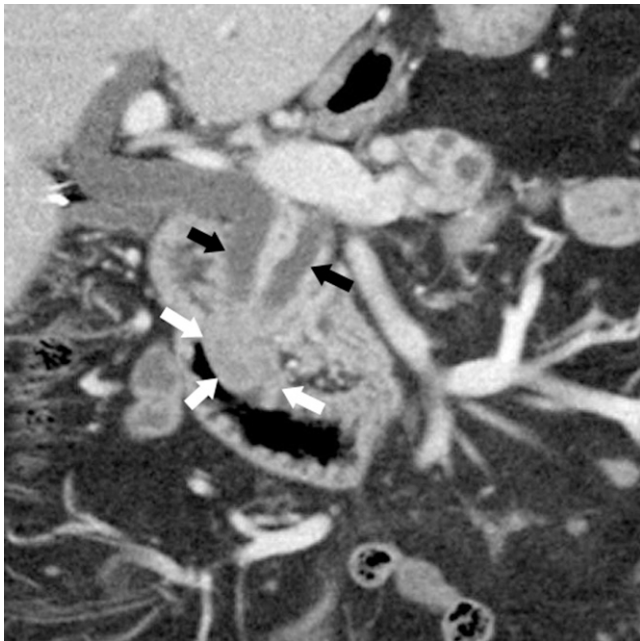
Coronal CT image through the upper abdomen in a 45-year-old male patient with painless jaundice showing a “mushroom”-shaped lesion consistent with an ampullary tumour (white arrows). Note double-duct sign (black arrows) point to abrupt cut off and dilatation of the common bile duct and pancreatic duct.
